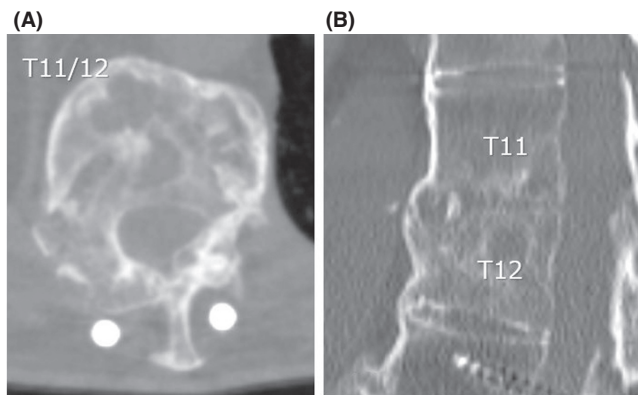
Computed tomography at 6 months after surgery: (A) axial section at T11/12 level, (B) sagittal section. The bone union was achieved between vertebral bodies of T11 and T12.
